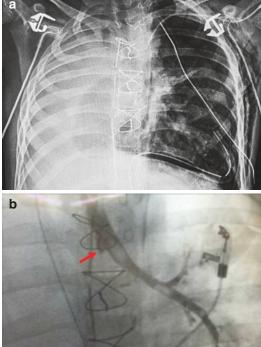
(a) X-rays after right neumonectomy in a 7 yo. There is a left neumothorax in the post-operative day 3. Right bronchial leaking is suspected. (b) TBG is performed day 3 and shows no leaking through the right
